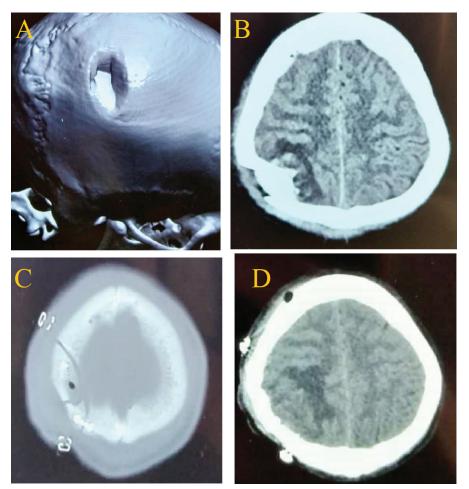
Preoperative 3D CT image showing right parietal depressed fracture (A) and Axial CT image showing right parietal depressed fracture with contusion; Postoperative 3D CT image showing elevated fracture(C) and Axial CT image showing resolving contusion (D).
